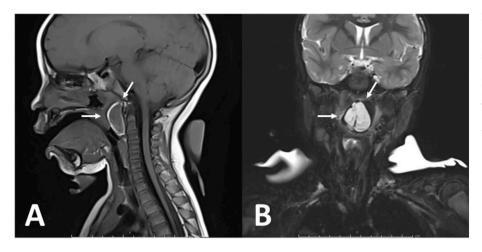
(A) Mid-sagittal T1-weighted MRI revealing intermediate intensity, submucosal, cystic lesion in the midline prevertebral space of the nasopharynx measuring 1.5×2.9 cm. The mass displaces the adenoid tonsil and soft palate and narrows the nasopharynx. There is no intradural or intracranial communication nor periosteal reaction. (B) Coronal T2-weighted MRI with fat suppression revealing a 2.6×2.9 cm, non-enhancing, midline cystic mass with internal heterogeneous intensity and few thin internal septations.
